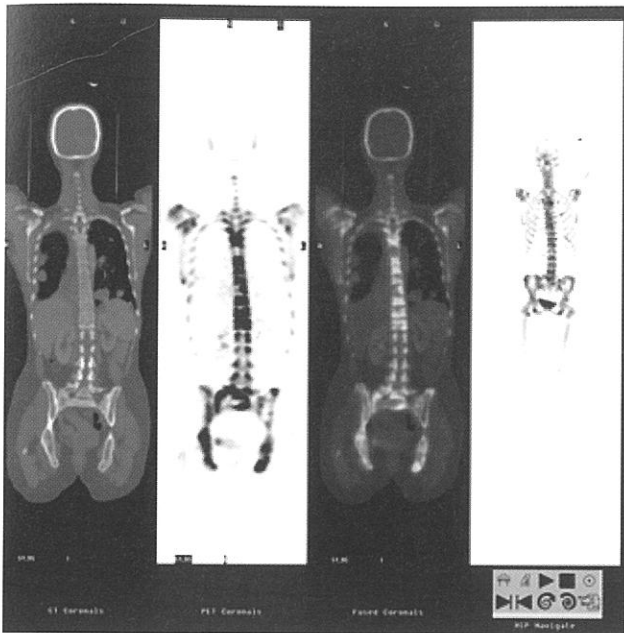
^{18}F -Sodium Fluoride (NaF) PET scan for evaluating skeletal metastasis. NaF PET/CT is an extremely sensitive method for detecting bony metastases in patients with known malignancy. NaF normally accumulates in the bones and areas of active soft tissue calcification with renal excretion into the bladder
